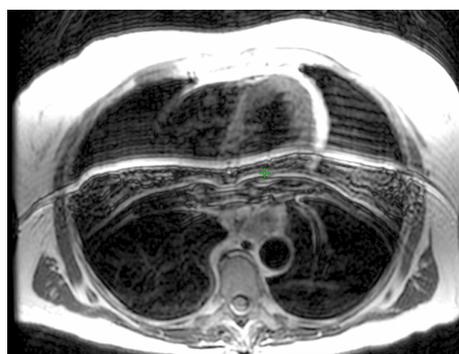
T2-weighted MR image with an IR FRSE sequence. The motion artefacts in the image make it difficult to delineate the oesophageal tumour. These images were not used for treatment planning.
